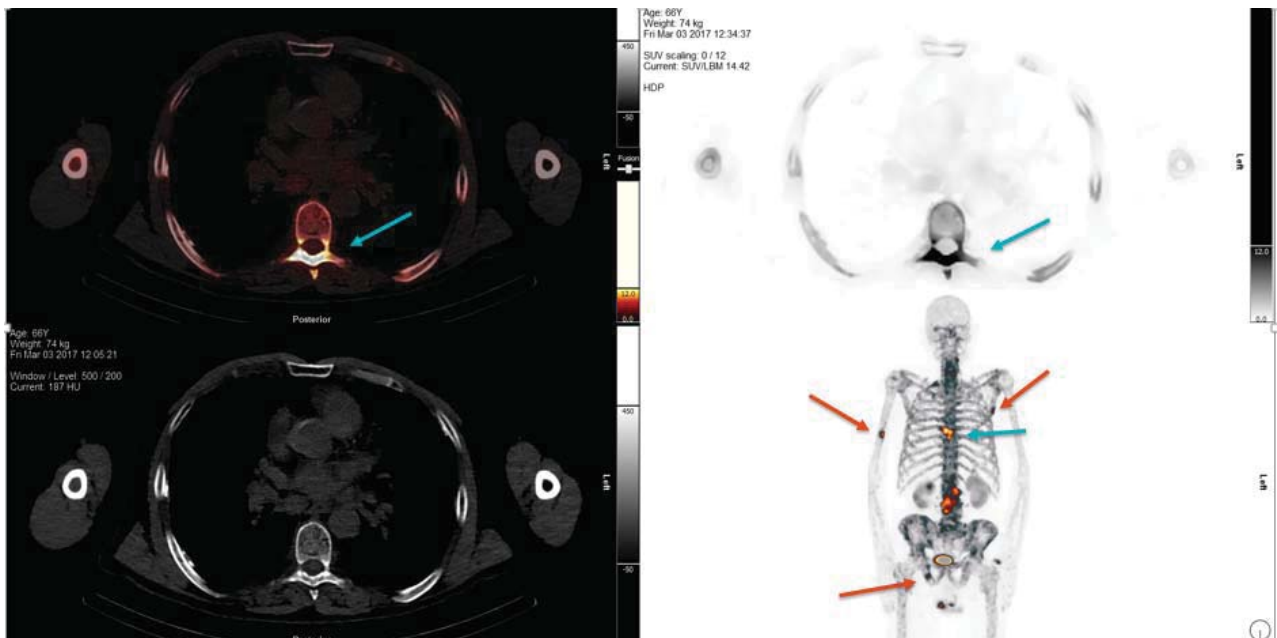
Case 3: SPECT images, SPECT/CT image and CT image (arrows = metastases, SUV/LBM max 14.42)
